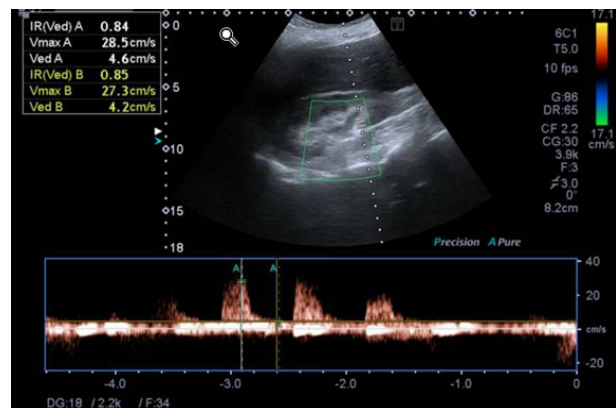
Renal Doppler ultrasound of the right kidney.
